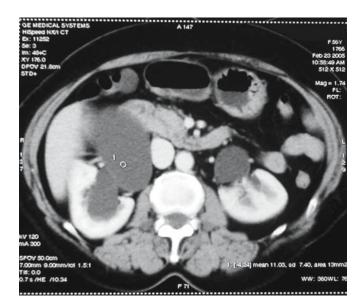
Computed tomography (CT) scan shows gross right hydronephrosis
